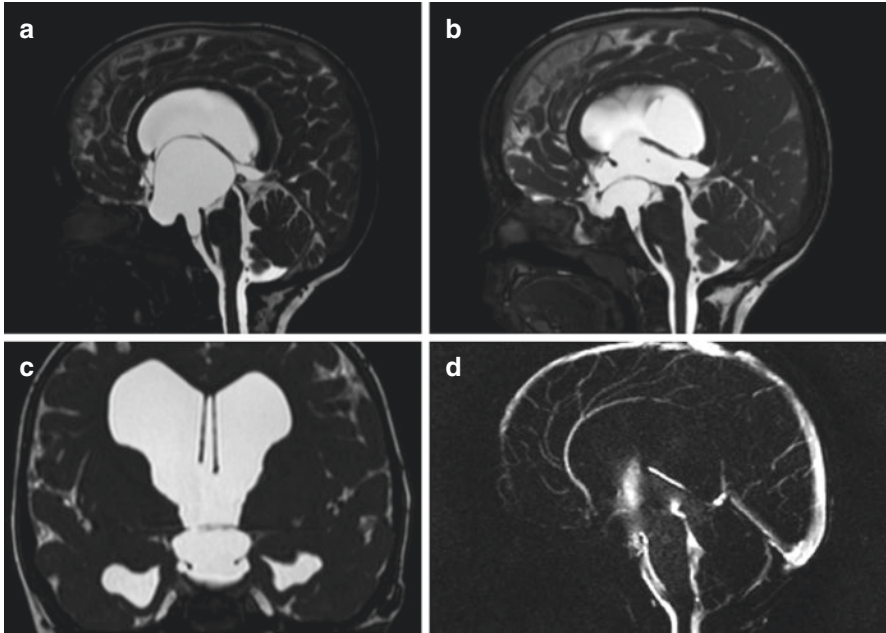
(a) Midsagittal CISS MR image showing the suprasellar AC with aqueduct occlusion. (b) Midsagittal CISS MR image 4 years after surgery showing decrease in size of AC and free aqueduct. (c) Coronal CISS MR image showing the fenestration of the roof of the AC. (d) CINE Phase MR Image showing the flow at roof and floor of AC after successful ventriculocystocisternostomy
